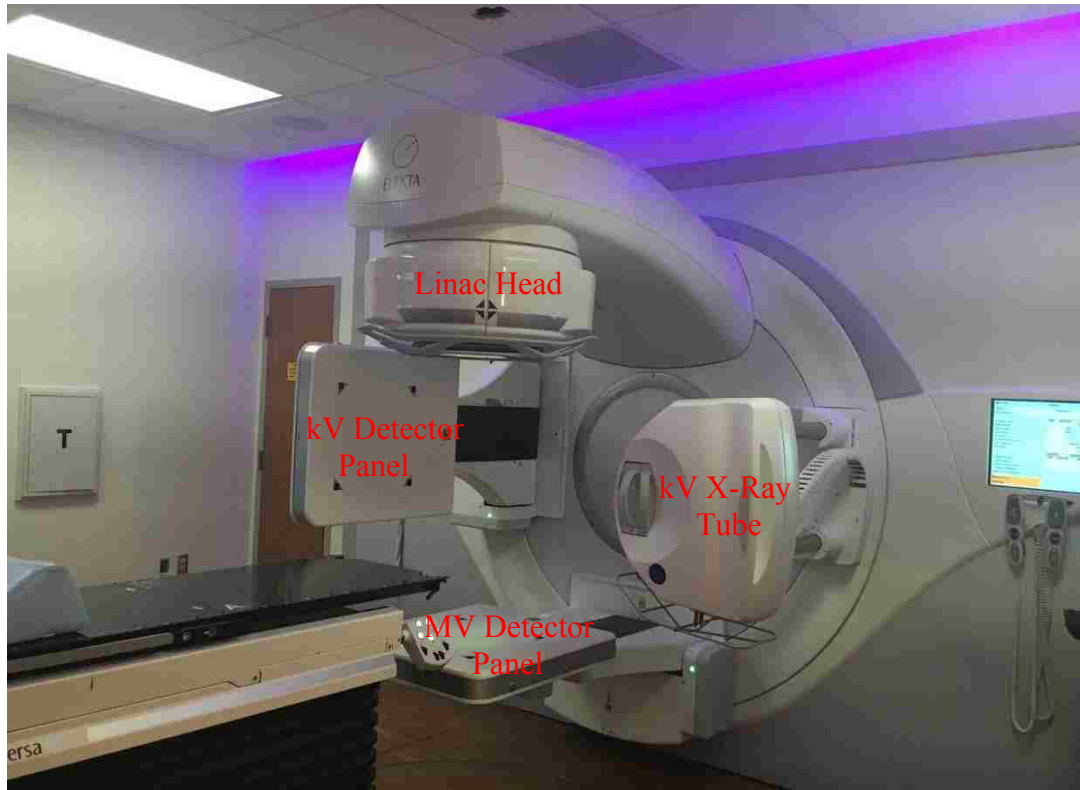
Mary Bird Perkins Cancer Center Elekta Versa HD linear accelerator with onboard MV-CBCT and orthogonal kV-CBCT imaging.
